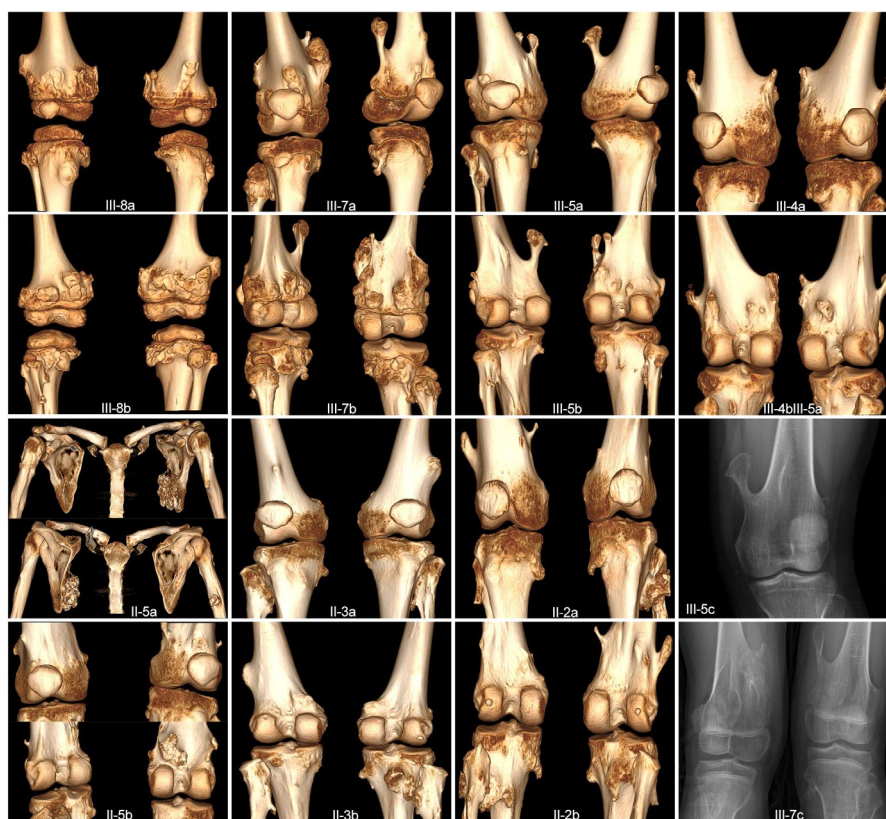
CT images and X-ray of patients show multiple lesions in the knee joint, growing away from the joint, visible bone protrusions, and cartilage caps, different patients, the length of the bone protrusions are different. One patient (II-5a) showed multiple lesions on the right scapula, and the lesions fused into a lesion. These lesions can also accumulate other bones. III-5c and III-7c is X-ray results, and the other pictures are CT image results
